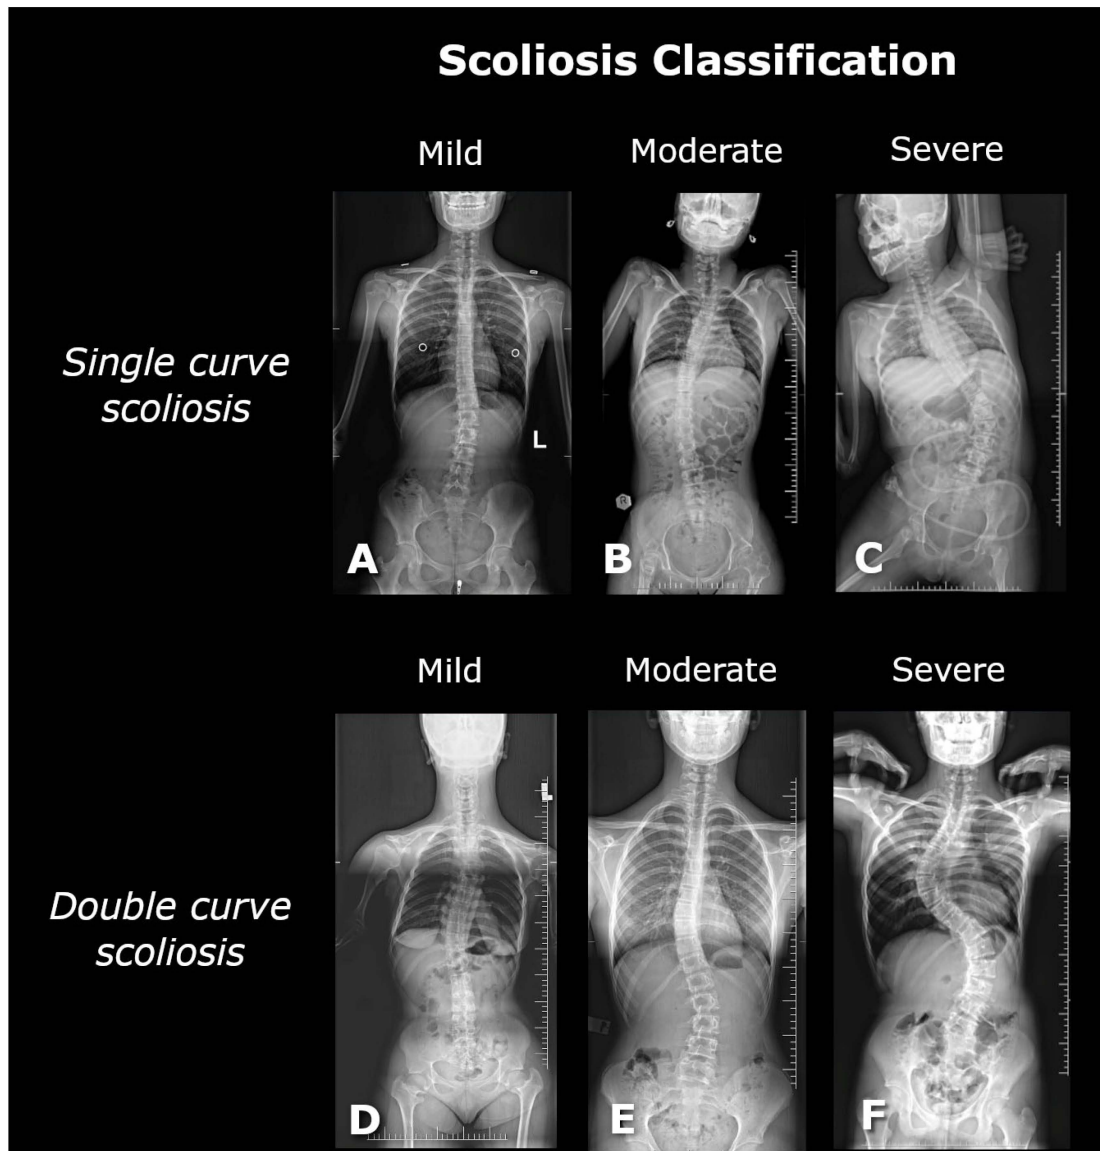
The figure shows posturographic X-ray images of single-curve scolioses at different stages: (A) mild (17° Cobb, L3/L4–Th12/Th11), (B) moderate (29° Cobb, L3/L4–Th7/Th6), (C) severe (56° Cobb, L4/L5–Th10/Th9), and double-curve scolioses: (D) mild (17° Cobb, L1/L2–Th9/Th8; 18° Cobb, Th8/Th7–Th2/Th1), (E) moderate (26° Cobb, L4/L5–L1/Th12; 25° Cobb, L1/Th12–Th8/Th7), and (F) severe (75° Cobb, L4/L5–Th12/Th11; 78° Cobb, Th11/Th10–Th5/Th4).
